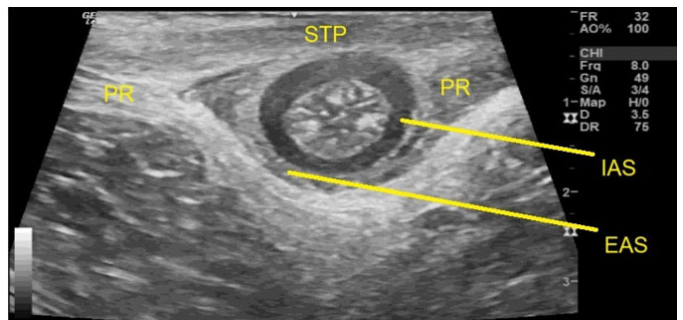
Ultrasound image of the patient's external anal sphincter (EAS) six months post-first PRP treatment showing return to proper circular morphology. Again, the superficial transverse perineum (STP), puborectalis (PR), and internal anal sphincter (IAS) are labeled for anatomic clarity.
